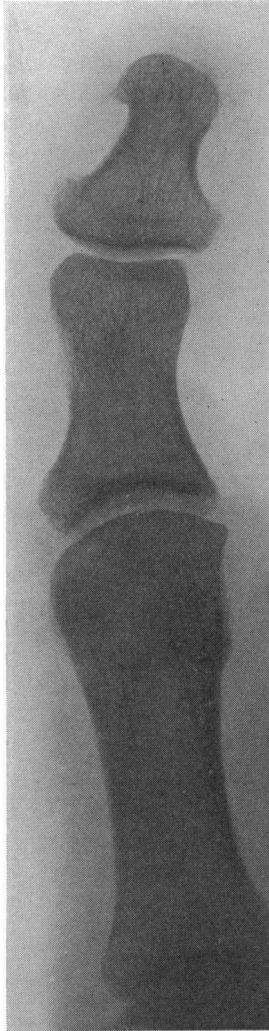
Radiograph of a right great toe. The shaft of the terminal phalanx is not set at right angles to its articular surface.
